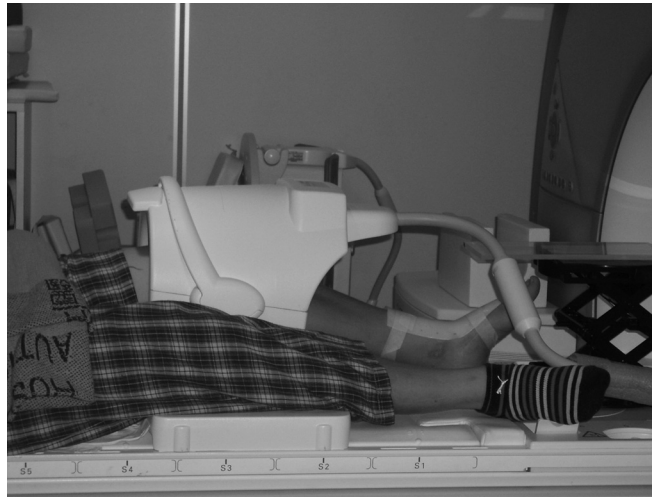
Positioning of patient for MRI. The subject is required to extend to knee to 20-degree flexion with the big toe touching the plastic board. MRI indicates magnetic resonance imaging.
